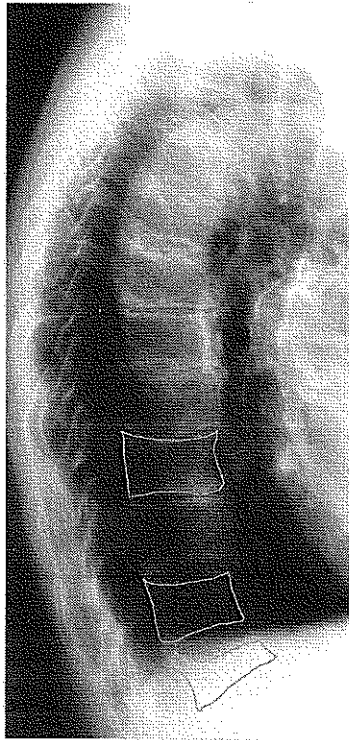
X-ray showing previous vertebral fractures.
